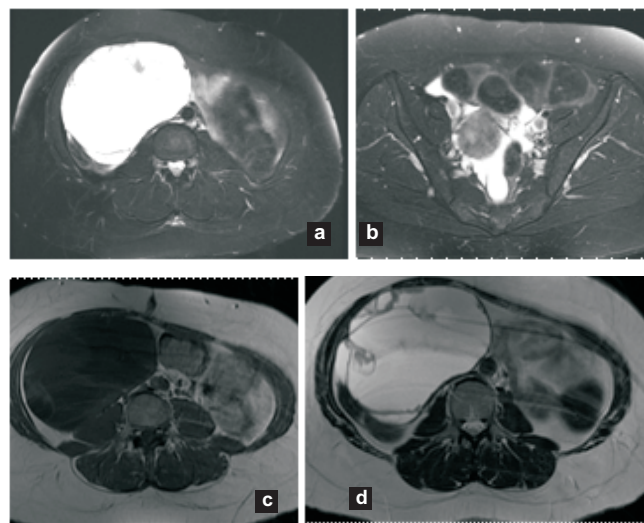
Malignant serous cystadenocarcinoma: (a) T2W FS AX (b) T2W FS AX (c) T1W AX (d) T2W AX: Large multiseptated predominantly cystic lesion with thick septae, papillary excrescences and solid nodules. Marked ascites noted. Large size of the cyst and ascites may point towards malignancy; however difficult to differentiate between the benign and malignant neoplasm on MR imaging.
